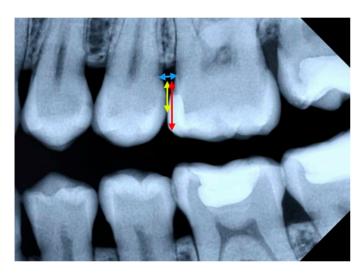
Bitewing radiography. Distances measurements.
